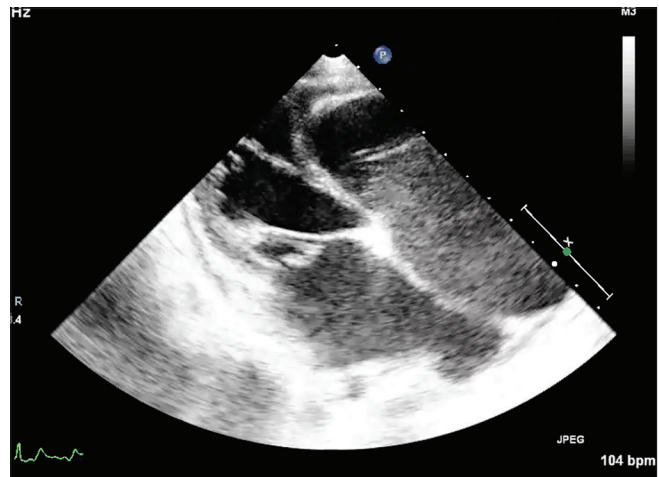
Four-chamber echocardiographic view showing nearly complete obliteration of right ventricular cavity with involvement of left ventricle as well
